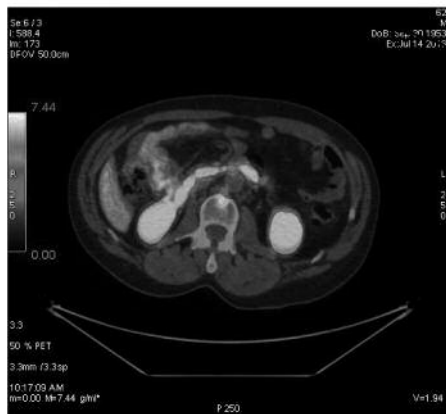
the ^{68}Ga -PSMA PET/CT performed in July 2016 revealed tracer uptake in L2 vertebra.
